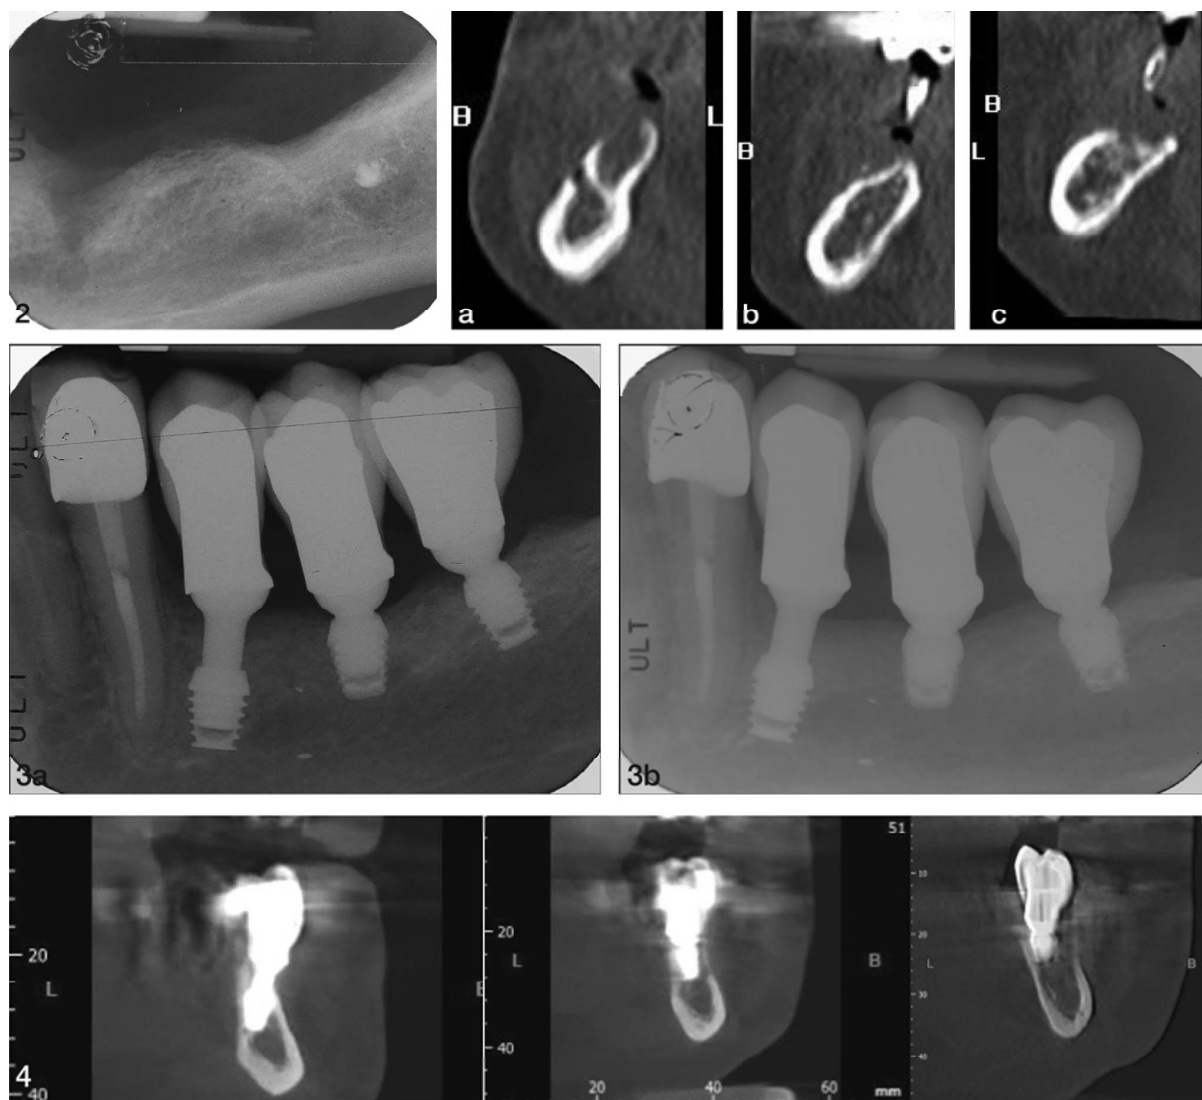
FIGURE 2. 3 implants (4.0×5.0 mm, 4.0×5.0 mm, and 4.0×5.0 mm) placed in #21, #19, and #18 sites. (a) Pre-operative radiograph before implant placement. (b) Cone beam computerized tomography obtained before implant placement. FIGURE 3. 3 implants (4.0×5.0 mm, 4.0×5.0 mm, and 4.0×5.0 mm) placed in #21, #19, and #18 sites. (c) X ray obtained at loading time; (d) X ray obtained at 3-year follow-up. FIGURE 4. Three implants (4.0×5.0 mm, 4.0×5.0 mm, and 4.0×5.0 mm) placed in #21, #19, and #18 sites. Cone beam computerized tomography obtained at 3-year follow-up.
